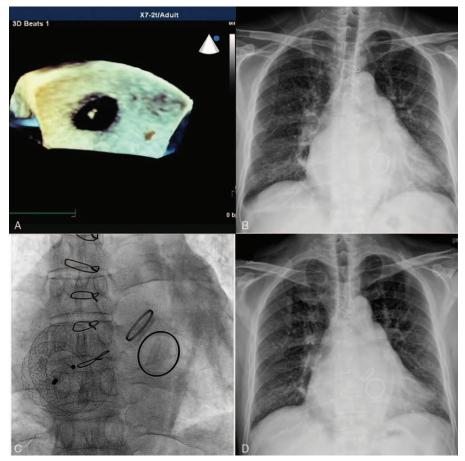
(A) Preprocedure transesophageal echocardiogram revealed a 20 × 33 mm atrial septal defect. (B) Preprocedure chest radiograph showed pulmonary edema. (C) Immediate postprocedure radiograph demonstrated the occluder did not impede the opening and closing of the mechanical valves. (D) Postprocedure chest radiograph obtained at 6 months showed pulmonary edema disappeared.
